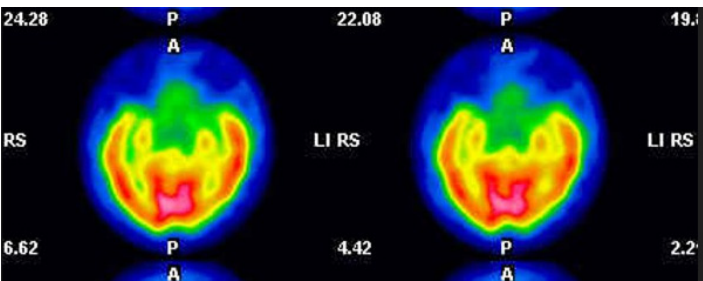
ECD single photon emission computed tomography (ECD-SPECT) of this patient. discloses peculiar hyperperfusion in bilateral. SPECT findings showing the abnormal bilateral hyperperfusion of the amygdalae.
